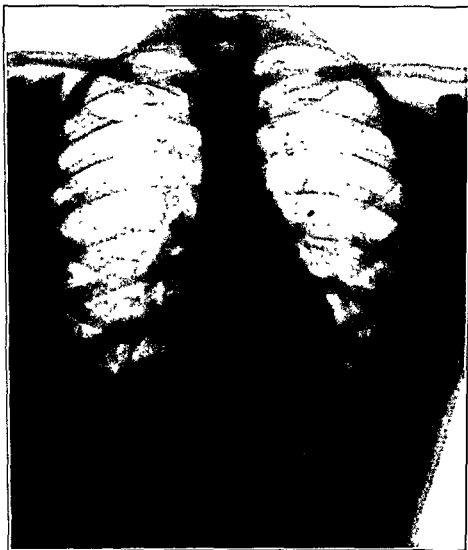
An x-ray of Case No. 3 demonstrating the rapid resolution which may take place in benign exudative tuberculosis. Forty-nine days have elapsed since the x-ray demonstrated in Fig. 25.
